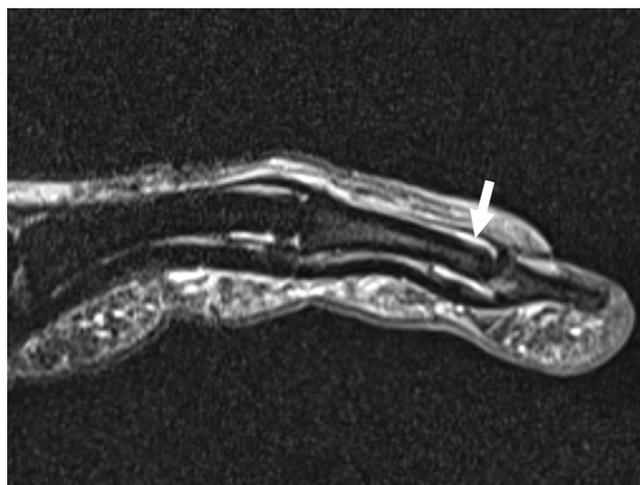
MRI of the long finger, showing distal interphalangeal joint effusion (arrow).
